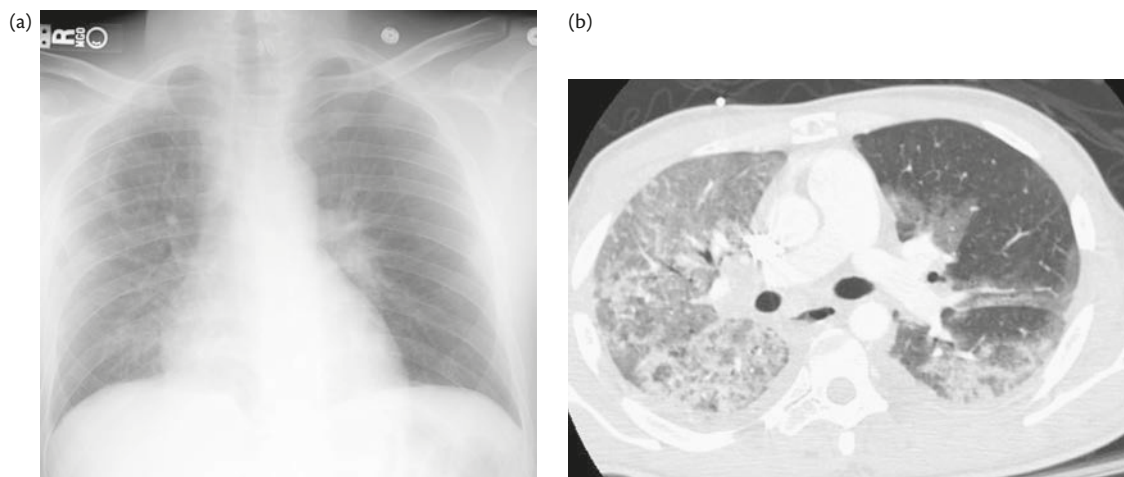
Case 7. (a) X-ray; (b) CT scan.
